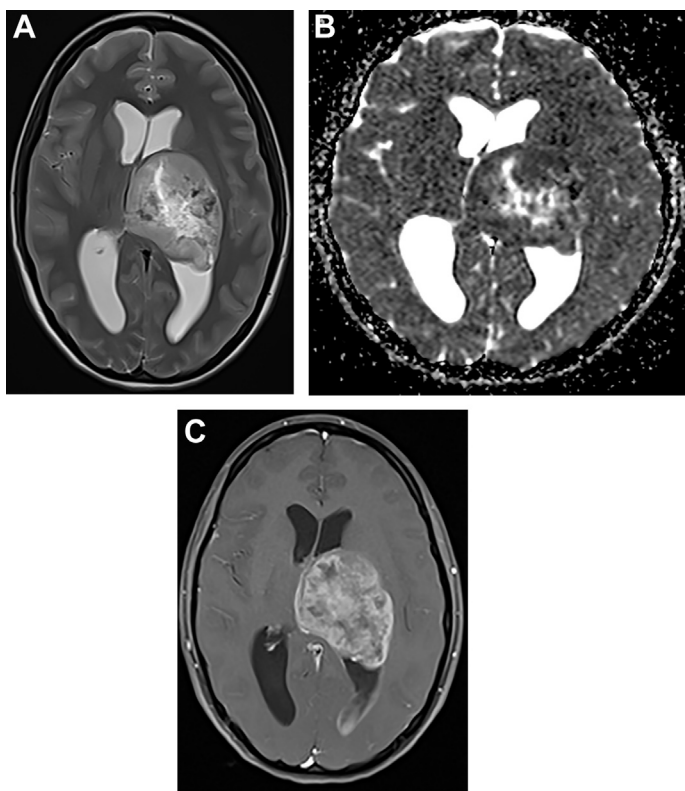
Diffuse midline glioma with H3 K27M mutation. Axial T2-weighted image (A) demonstrates heterointense mass centered over the left thalamus with well-defined margins and without perilesional edema. On axial ADC image (B), mass shows low ADC except in the region of the necrosis. Contrast-enhanced T1-weighted image (C) shows intense enhancement of the thalamic mass with leptomeningeal enhancement along the left trigone and occipital horn.
